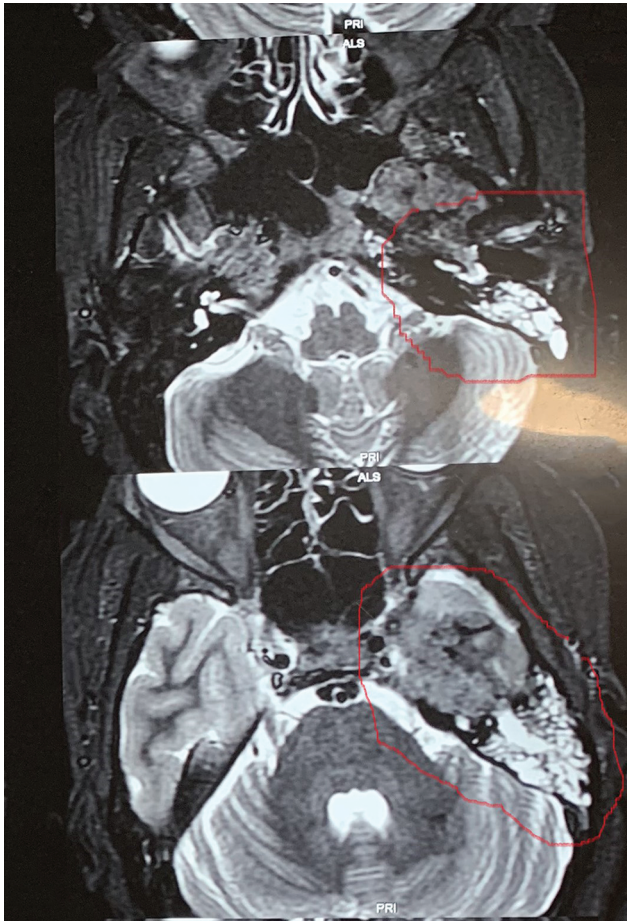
MRI showing left infratemporal space occupying lesion.
